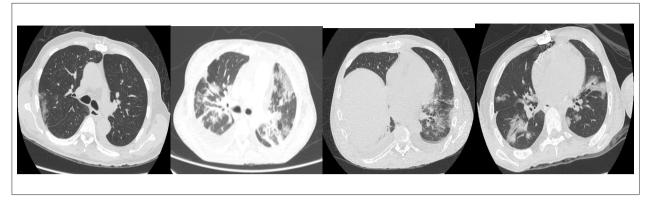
Chest computed tomography revealing peripheral ground glass opacities in case 1 (A), case 2 (B), case 3 (C) and case 4 (D).
